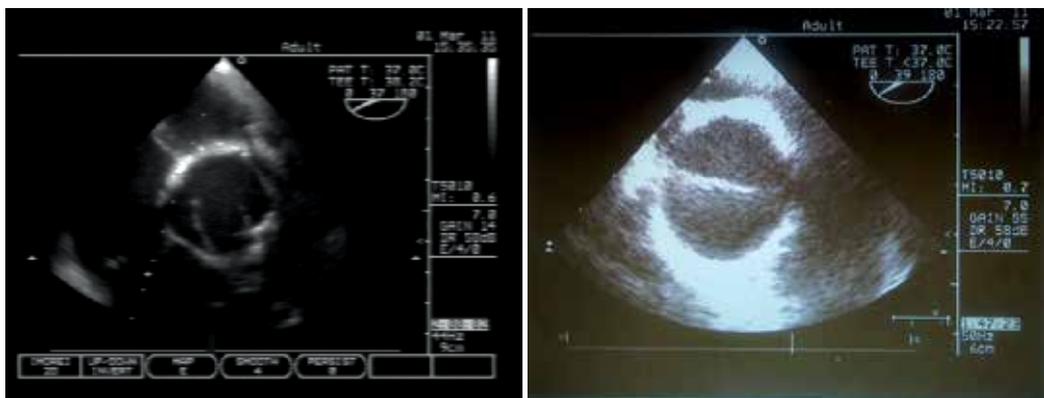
TTE: (a) Parasternal short axis view: BAV during systole, (b) Parasternal short axis view: aortic valve area
